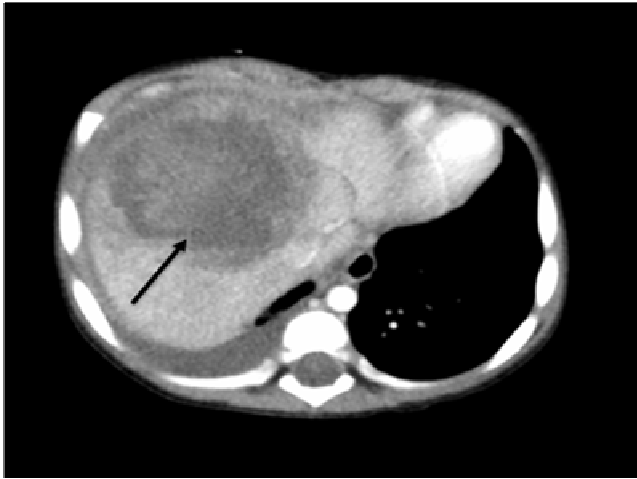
Contrast-enhanced CT scan of abdomen showed a large semi-liquid mass in the right lobe of the liver, suggestive of liver abscess.
